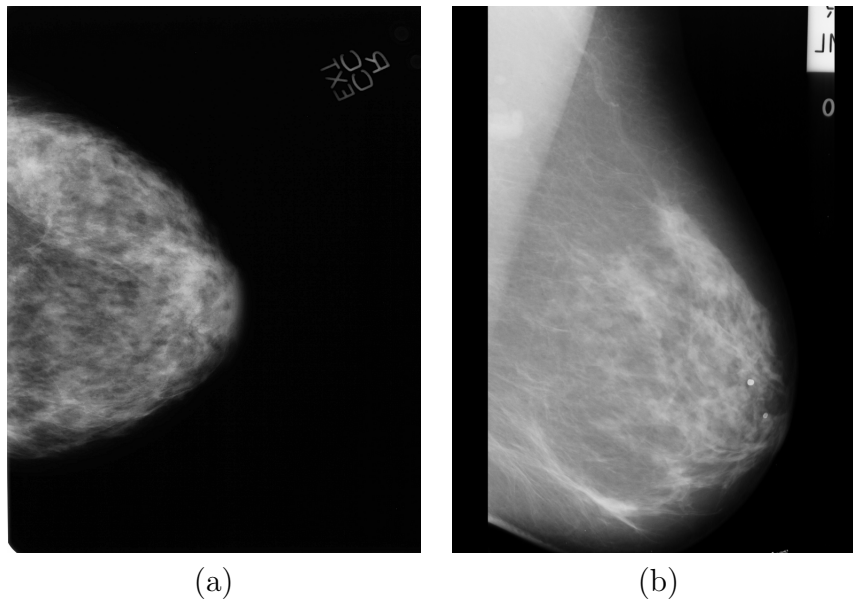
Mammographic images obtained under different projection angles of the X-rays system. (a) Cranio-caudal view, (b) Mediolateral oblique view.
